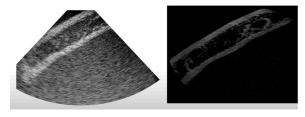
Ultrasound image generated (Left) matched by the corresponding CBCT XY-slice (Right)
